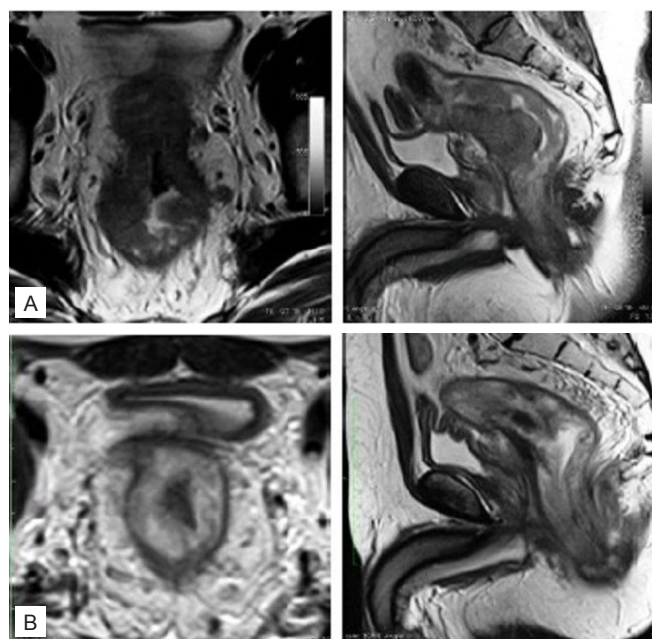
A: Magnetic resonance images of middle third locally advanced rectal cancer in a male patient before neoadjuvant chemoradiotherapy (CRT). B: Magnetic resonance images of the same patient after neoadjuvant CRT showing near complete response.
